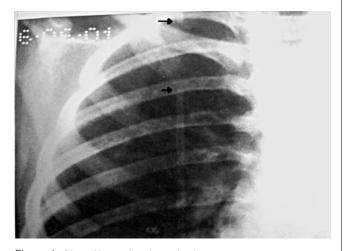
Chest X-ray showing tube fracture
